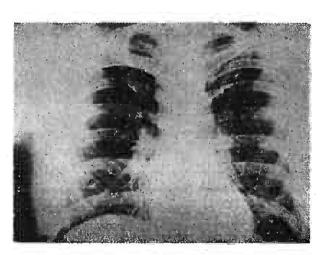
X-ray Chest. Note the almost complete disappearance of the opacity.
